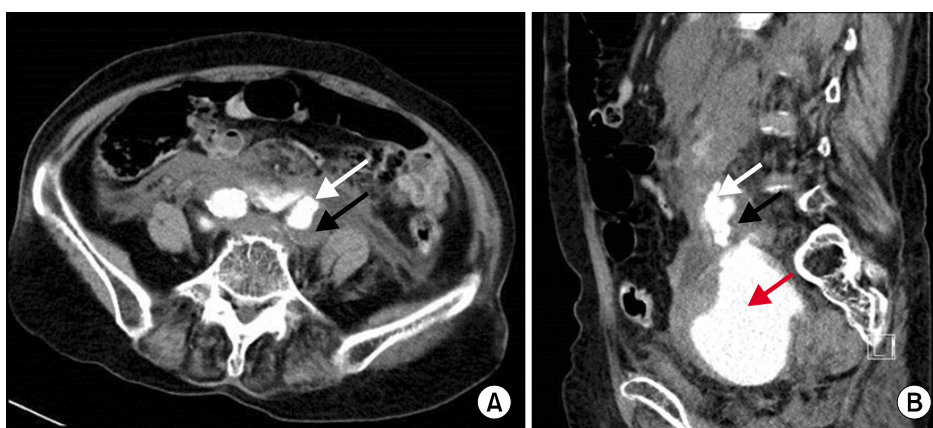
Enhanced whole abdominal computed tomography (CT). CT shows huge hematoma presenting as a leakage of dye (red arrow) on retroperitoneal space and a calcified large sized fusiform aneurysm containing thrombus and arising from left common iliac artery. There are true (white arrow) lumen filled with dye and false lumen (black arrow) occupied with thrombus inside of the vessel.
